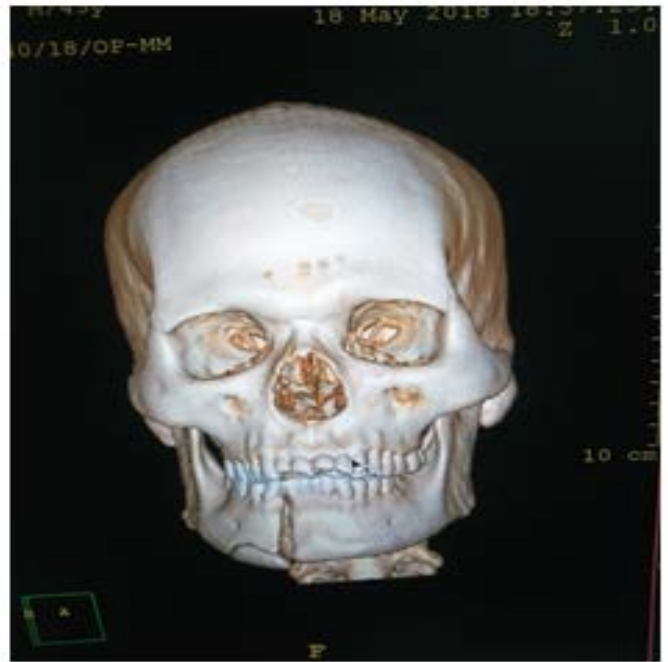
CT-Scan Pictures
